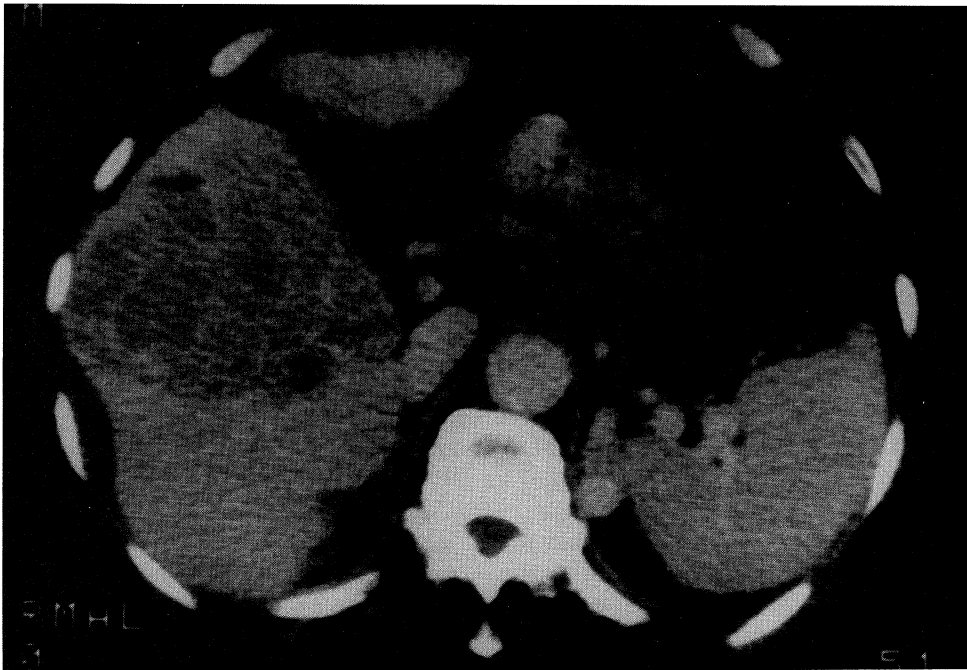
X ray-CT shows liver cancer and liver cirrhosis
